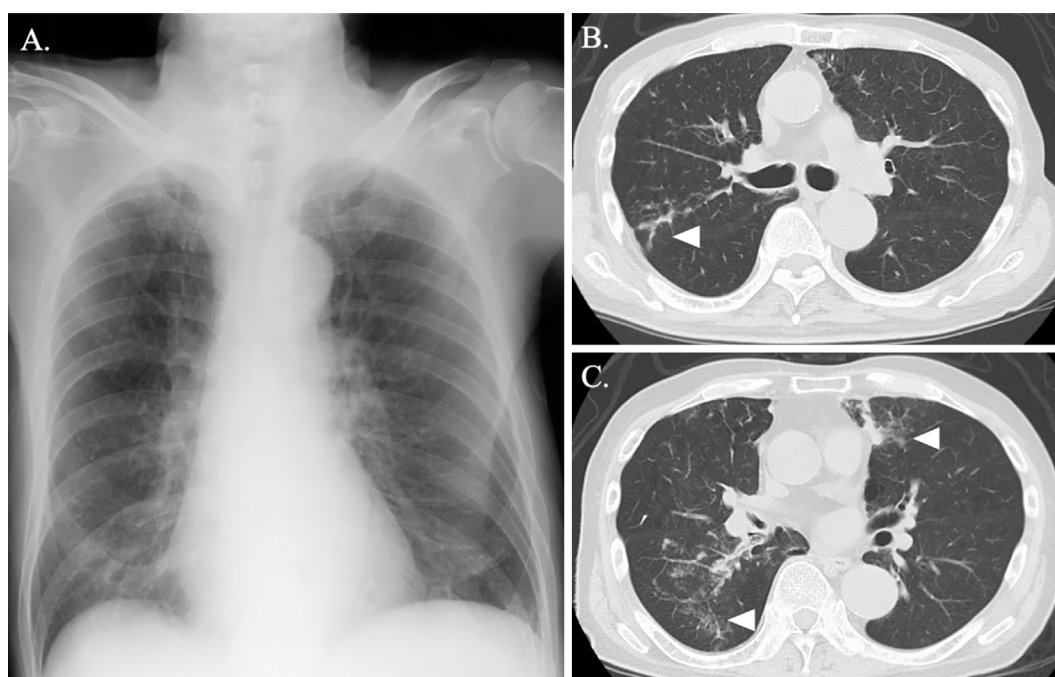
Chest X-ray showed small nodular shadows and ground-glass opacities in the right middle and lower lobes (A). High-resolution computed tomography revealed infiltrative and small nodular shadows in both lungs and ground-glass opacities in the right lower lobe (B and C) (arrowheads).
